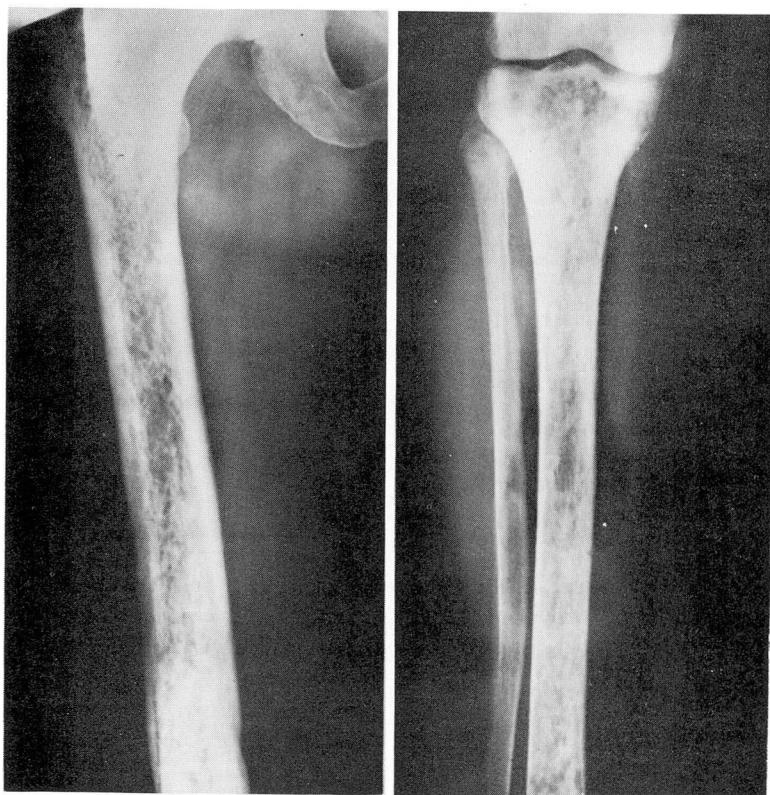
Roentgenograms of the femur and of the tibia and fibula, with evidence of numerous small radiolucent defects.
